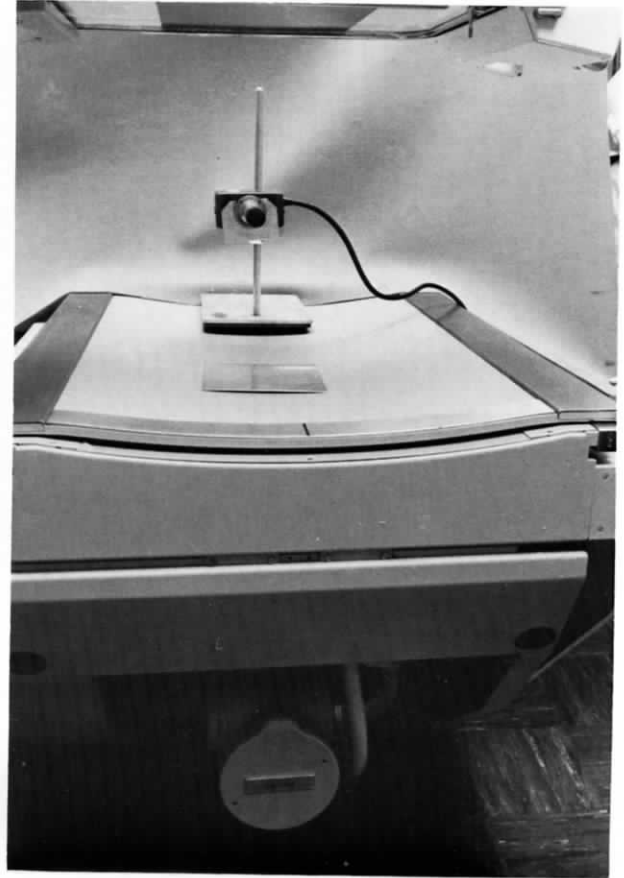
HVL measurement setup for an undertable x-ray tube with the aluminum filtration placed directly on the table and the intensifier raised as far from the ionization chamber as possible.
